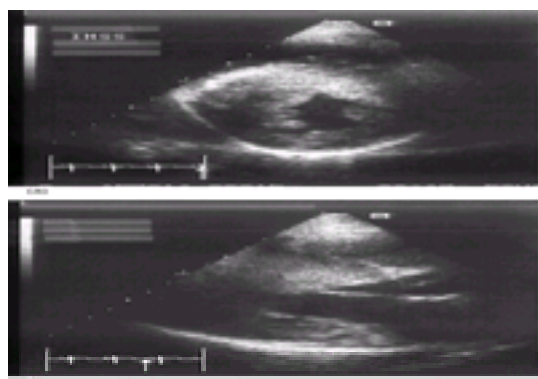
Typical echocardiogram of a patient with asymmetric septal hypertrophy; the massive septal hypertrophy is evident on both the short-axis (a) and long-axis (b) views.
